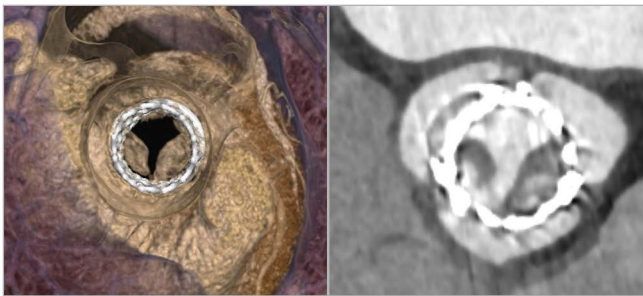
Computed tomography images showing a case of valve thrombosis after valve-in-valve TAVI.
